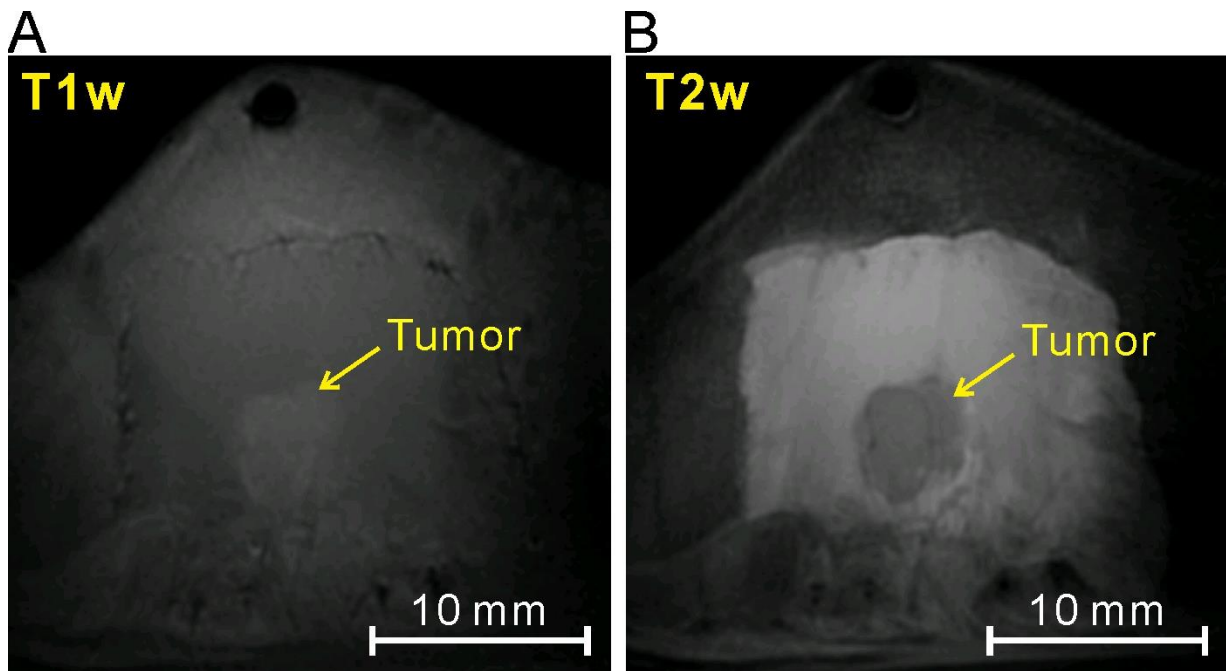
T1 weighted (A) and T2 weighted (B) MRI images of the window chamber.
